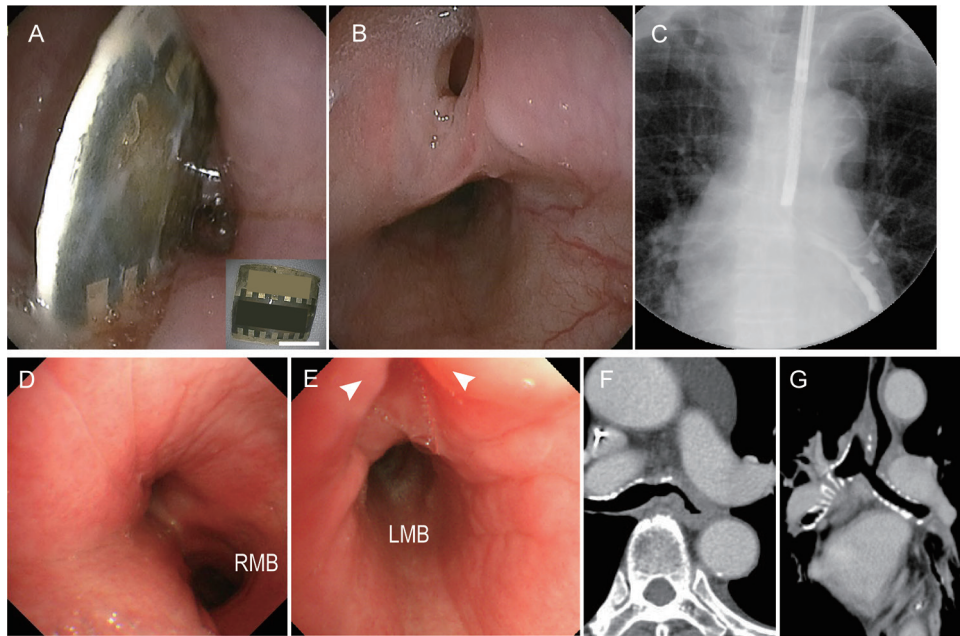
(A) Upper endoscopy shows a foreign body lodged in the esophagus. The inset is a photograph of the foreign body, which was a piece of thick paper measuring 2×2 cm. (B) Upper endoscopy performed 1 week after removal of the foreign body shows a deep indentation. (C) X-ray fluoroscopy with contrast medium injected through an endoscopic channel shows a fistula connecting to the LMB. (D) A bronchoscopic image shows mucosal redness and edema on the left side of the wall of the lower trachea and stenotic change at the orifice of the LMB. (E) A close-up bronchoscopic image of the orifice of the LMB shows a deep indentation in the thickened bronchial wall. (F) An enhanced CT image shows luminal continuity between the LMB and the esophagus. (G) The reconstructed frontal plane on CT also shows luminal continuity between the LMB and esophagus. LMB: left main bronchus; RMB: right main bronchus; CT: computed tomography
